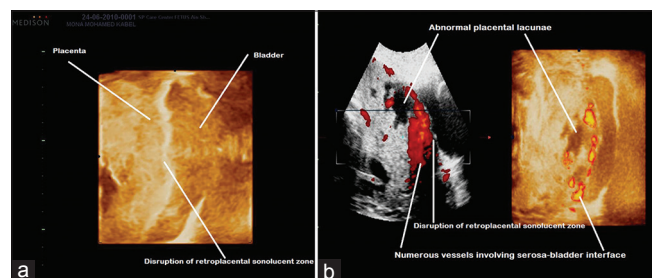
(a) Three-dimensional ultrasound of morbidly adherent placenta with disruption of retroplacental sonolucency. (b) Three-dimensional power Doppler of morbidly adherent placenta with numerous vessels involving serosa–bladder interface, disruption of retroplacental sonolucency zone, and abnormal placenta
